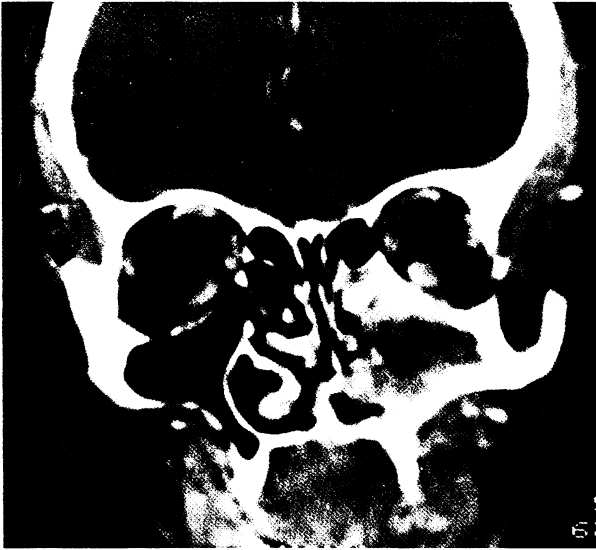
CT scan of carcinoma of left maxillary sinus.
